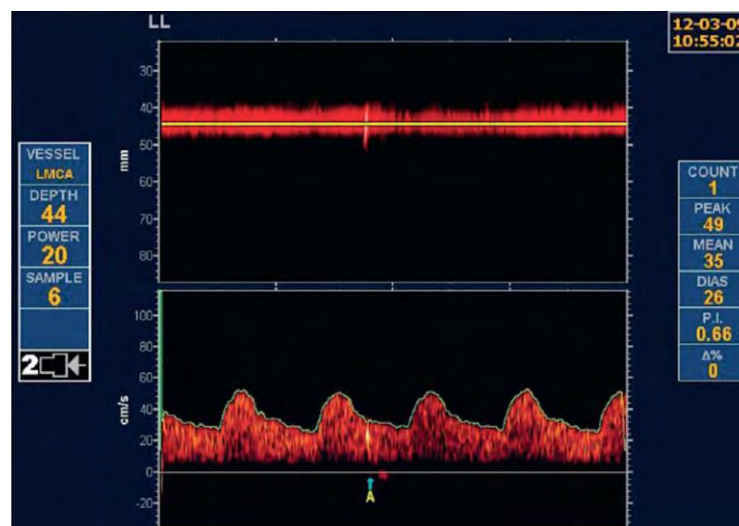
Microembolic signal on transcranial Doppler
